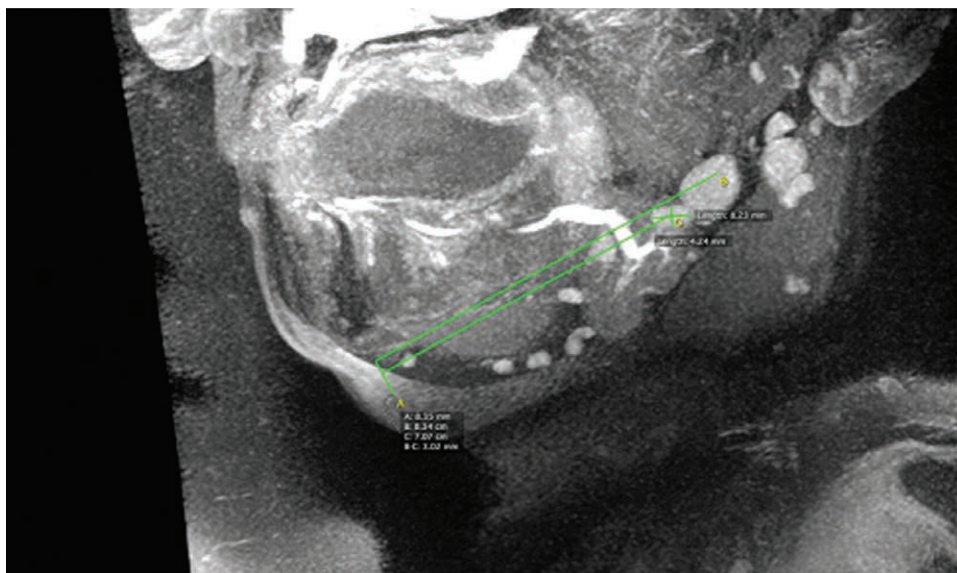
Magnetic resonance image (sagittal section) showing submental and submandibular lymph nodes distributed along a line drawn from the mental protuberance to the mandibular angle (green line).
